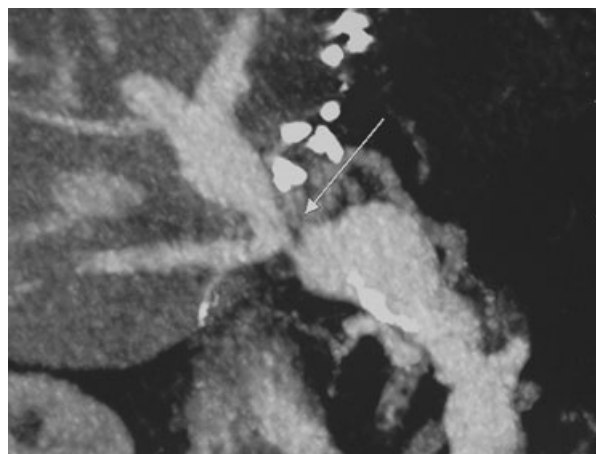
A 56-year-old male developed PV stenosis 22 months after living related liver transplant for cryptogenic chronic liver disease. CT scan shows PV with severe tight stenosis (arrow) with proximal dilatation. Note the venous backflow.
